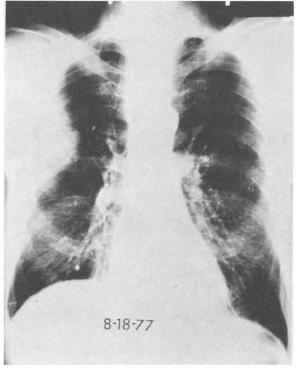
X-ray film of the chest made on admission showing right upper lobe pneumonia.
